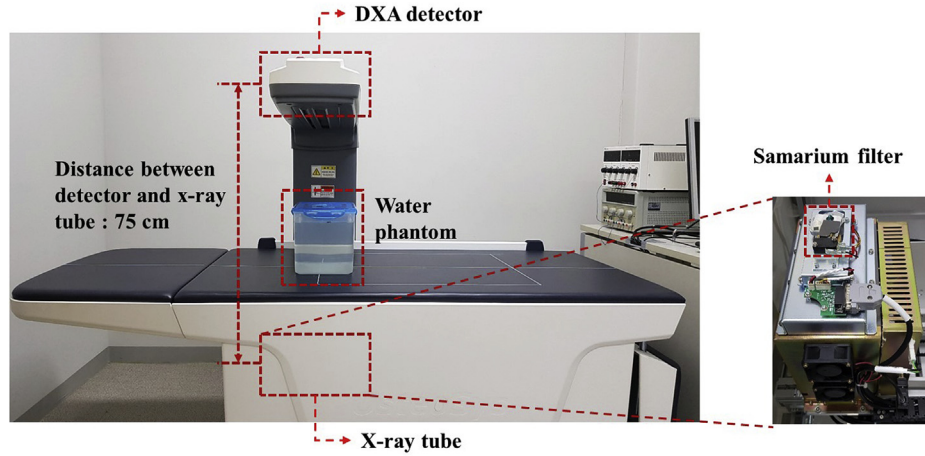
Experimental Setup of an X-ray tube and DXA detectors for performance evaluation.
